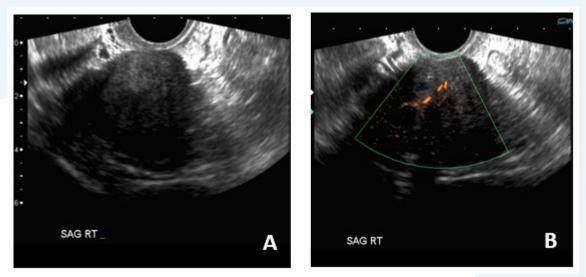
Gray scale and colour doppler images of a transvaginal ultrasound demonstrate the presence of a hypoechoic solid lesion in the right ovary >5 cm in size with acoustic shadowing.
